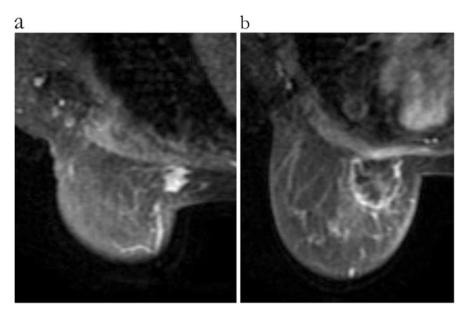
Contrast-enhanced MRI before and after RF ablation. (a) Before RF ablation. (b) After RF ablation
